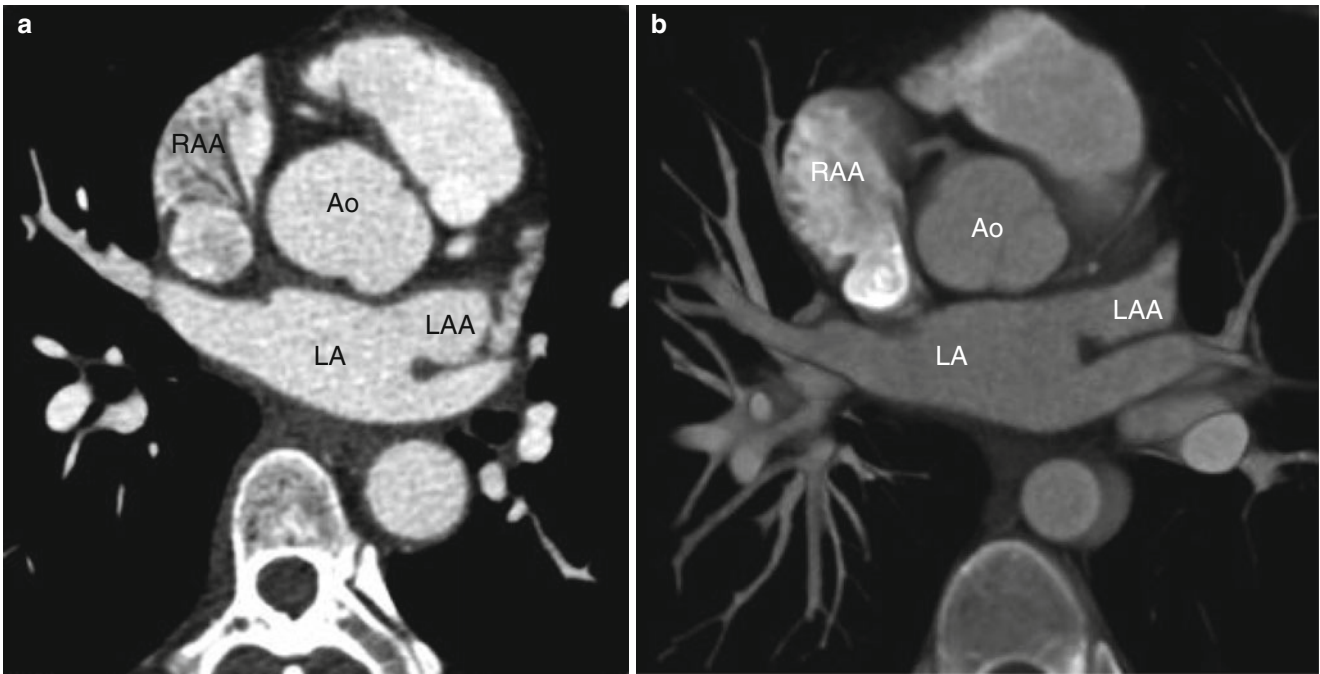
Atrial appendage morphology. Panels (a) and (b) are two axial computed tomography images. The right atrial appendage (RAA) is a blunt, broad-based structure lined with pectinate muscles that form
